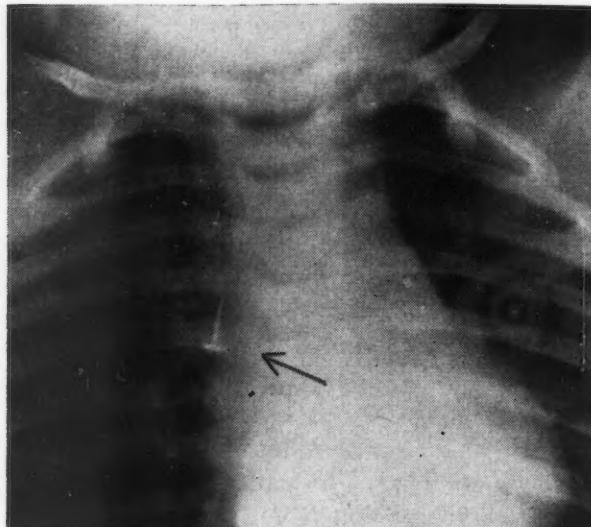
Tack in right main bronchus. P.M., age 11 months. July 10, 1936. Two days before admission, infant "swallowed" a small tack. Symptoms of cough, dyspnoea, wheezing and retraction of chest followed. The tack, visible in the right chest by x-ray, was removed by direct bronchoscopy under Avertin anaesthesia. Symptoms subsided in a week.
